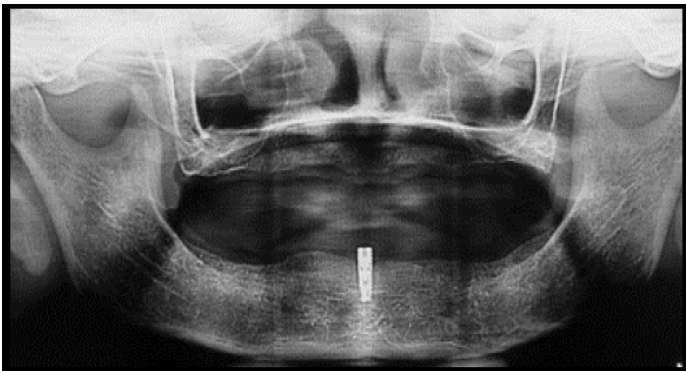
e. Radiographic evaluation of osseointegrated implants after 3 months
